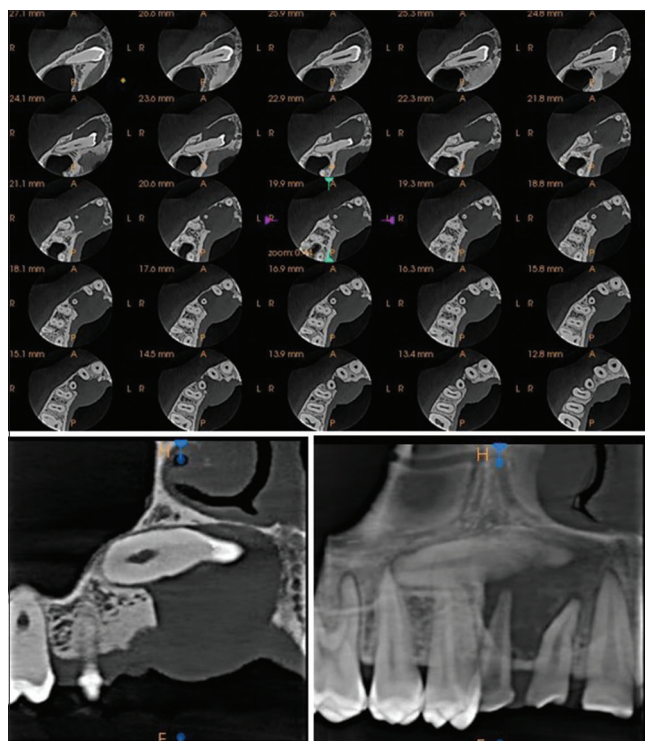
CT shows a well-defined, circumscribed, and low-density lesion at the right anterior maxilla with impacted teeth and mild displacement of the first premolar and lateral incisor
